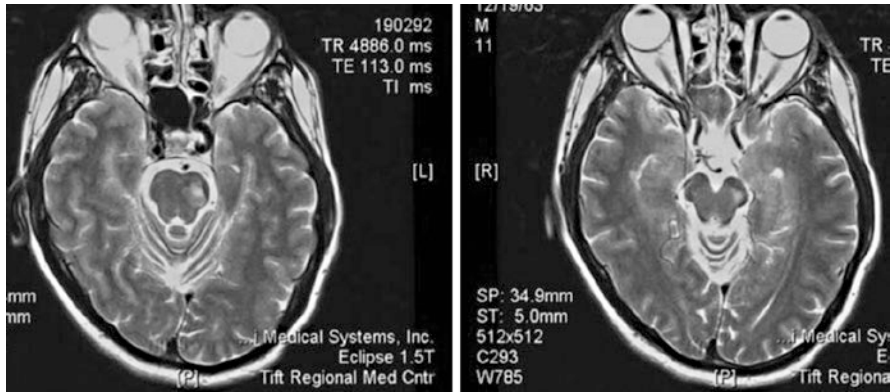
Brain MRI T2 axial sequence shows hyperintensity in the left cerebral peduncle
